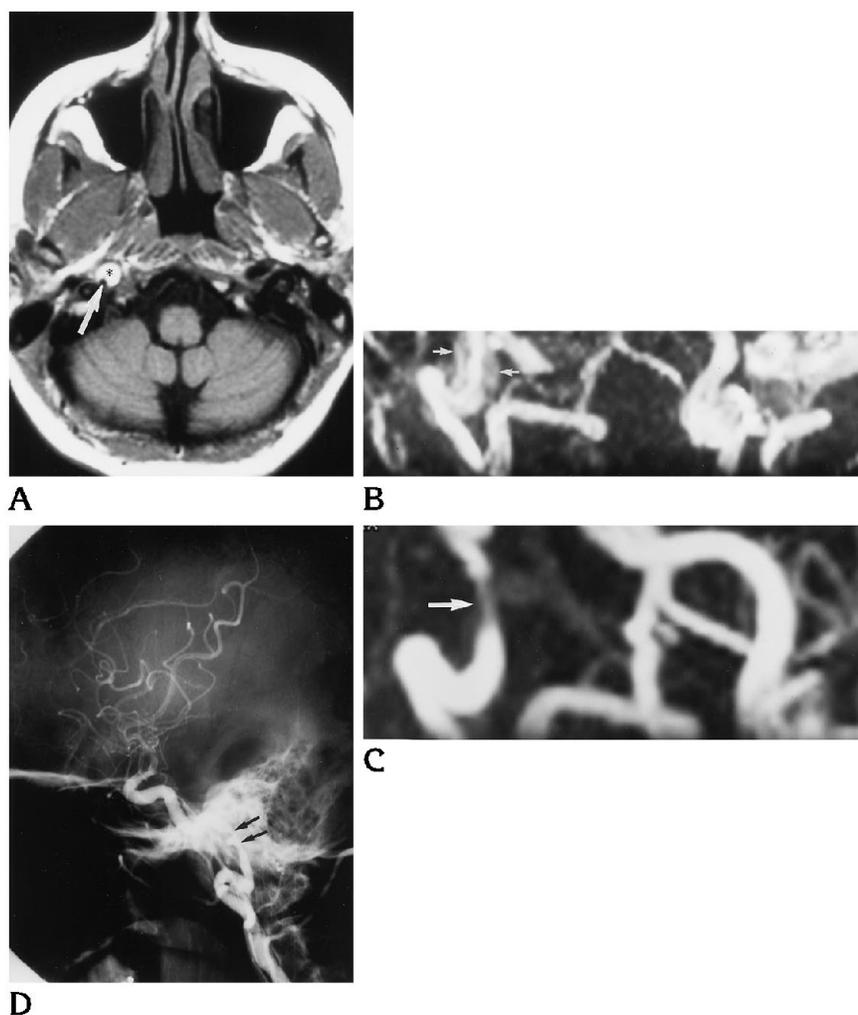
A, T1-weighted axial image demonstrates high-signal hematoma (*asterisk*) anterior to a narrowed right internal carotid artery lumen (*arrow*) (*crescent sign*).
